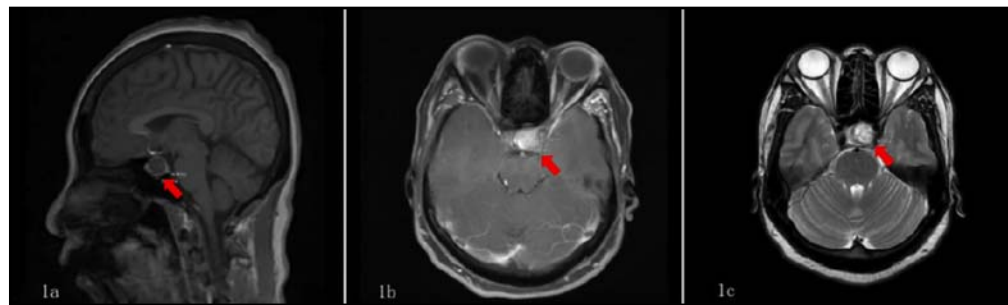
Pituitary gland magnetic resonance images (sagittal + axial).
